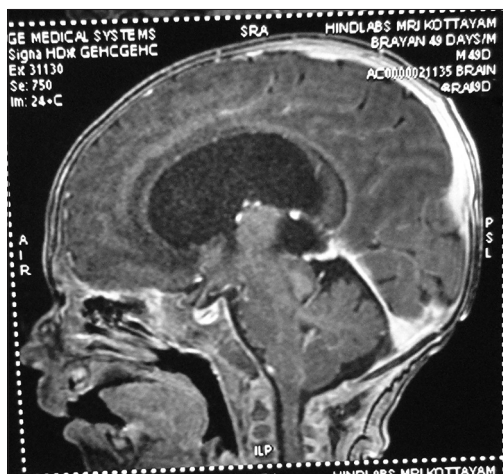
Magnetic resonance imaging of brain showing meningitis with obstructive hydrocephalus in 47-day-old infant with Methicillin-resistant *Staphylococcus aureus*
